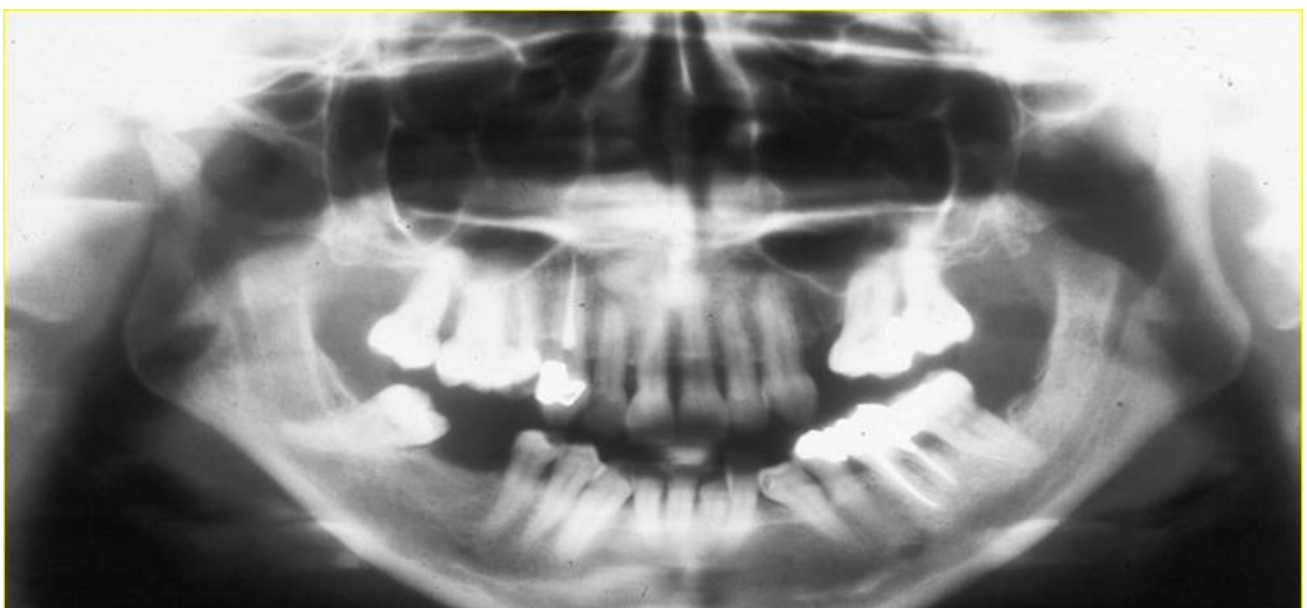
Panoramic radiograph with wide and blurry anterior teeth due to the patient positioned posterior to the focal trough.
